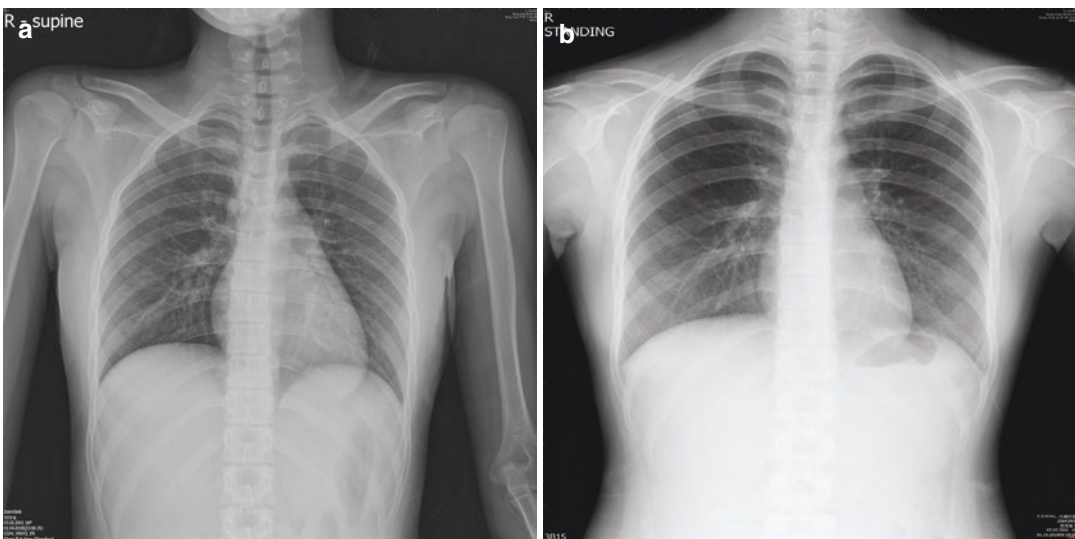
(a) Chest X-ray upon admission in a 16-year-old female adolescent (case 2) with pericarditis showed a normal cardiothoracic ratio (0.4). (b) Follow up chest X-ray
